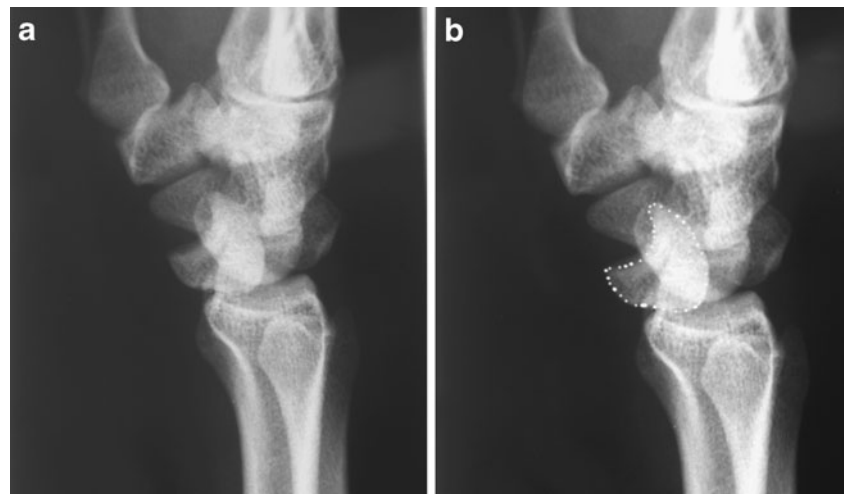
a Lateral radiograph of a stage III perilunate dislocation (same patient as in Fig. 1. b Same radiograph showing the lunate (*outlined*) is still articulating with the distal radius; however, there is dislocation of luno-capitate articulation. There is loss of co-linearity between the radius, lunate, and capitate
